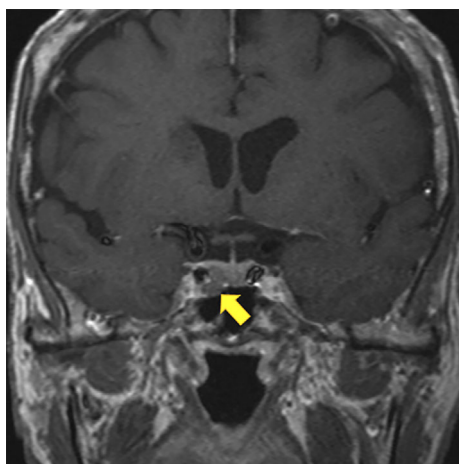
T1-weighted magnetic resonance imaging of the pituitary gland in the intermediate phase of gadolinium enhancement. A coronal magnetic resonance image showing a tumor 10.9×6.7 mm in size at the adenohypophysis adjacent to the right internal carotid artery (arrow).
